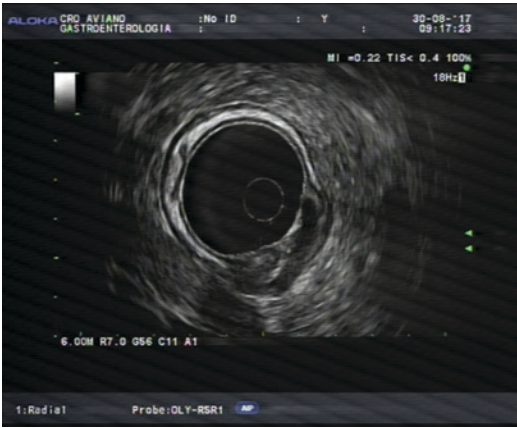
Endoscopic ultrasound image of gastric cancer T3N0
